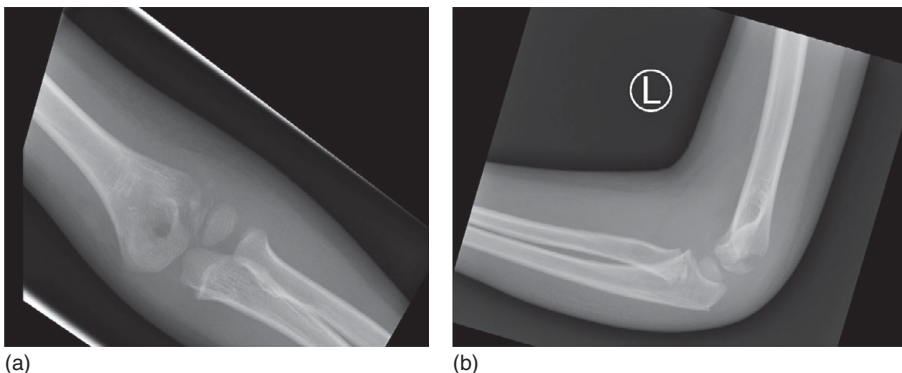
(a) Anteroposterior (AP) and (b) lateral radiograph child's elbow
